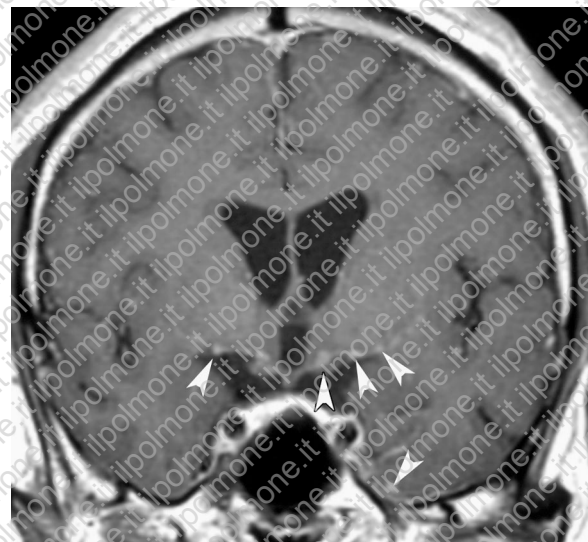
Leptomeningeal involvement in a 34-year-old man who presented with bilateral facial palsy. Coronal contrast-enhanced T1-weighted MR image shows enhancing miliary nodules covering the undersurface of the thalamus bilaterally, the hypothalamus, and the left temporal lobe (arrowheads).
